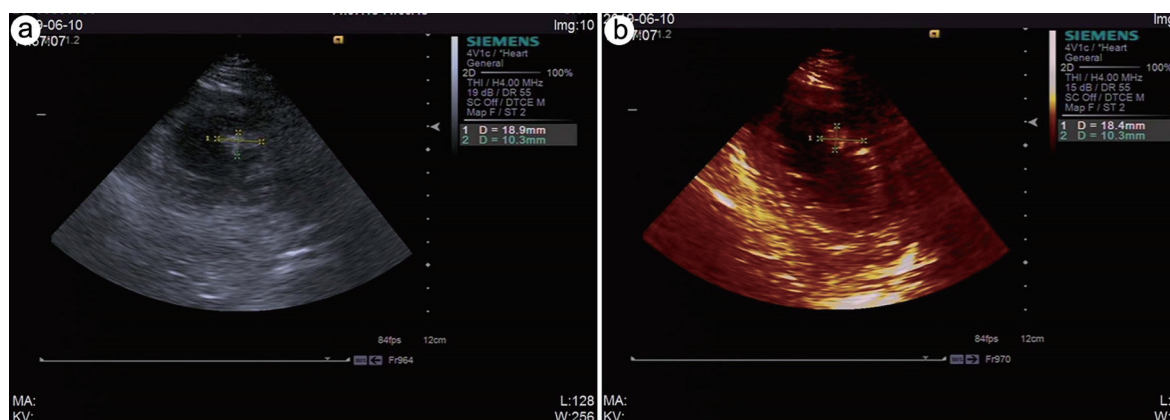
Rechecked UCG of case 1. UCG, ultrasonic cardiogram.
